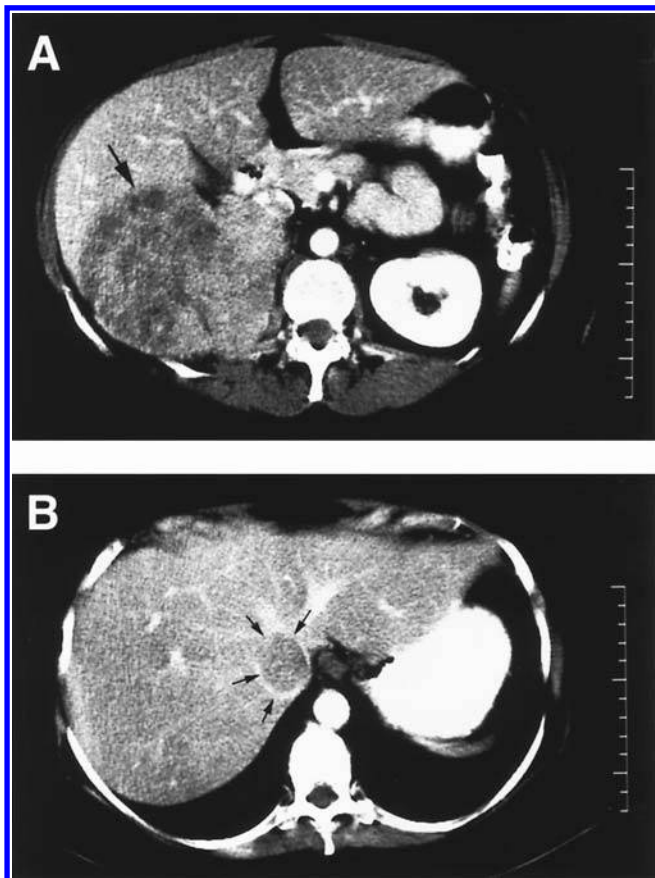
CT scan with intravenous contrast of a locally aggressive right adrenocortical cancer. The tumor appears to invade the right lobe of the liver (A) and is associated with a tumor thrombus in the inferior vena cava (B). The arrows in (B) outline the rim of the contrast-filled inferior vena cava around the tumor thrombus at the level of the insertion of the left and middle hepatic veins.
